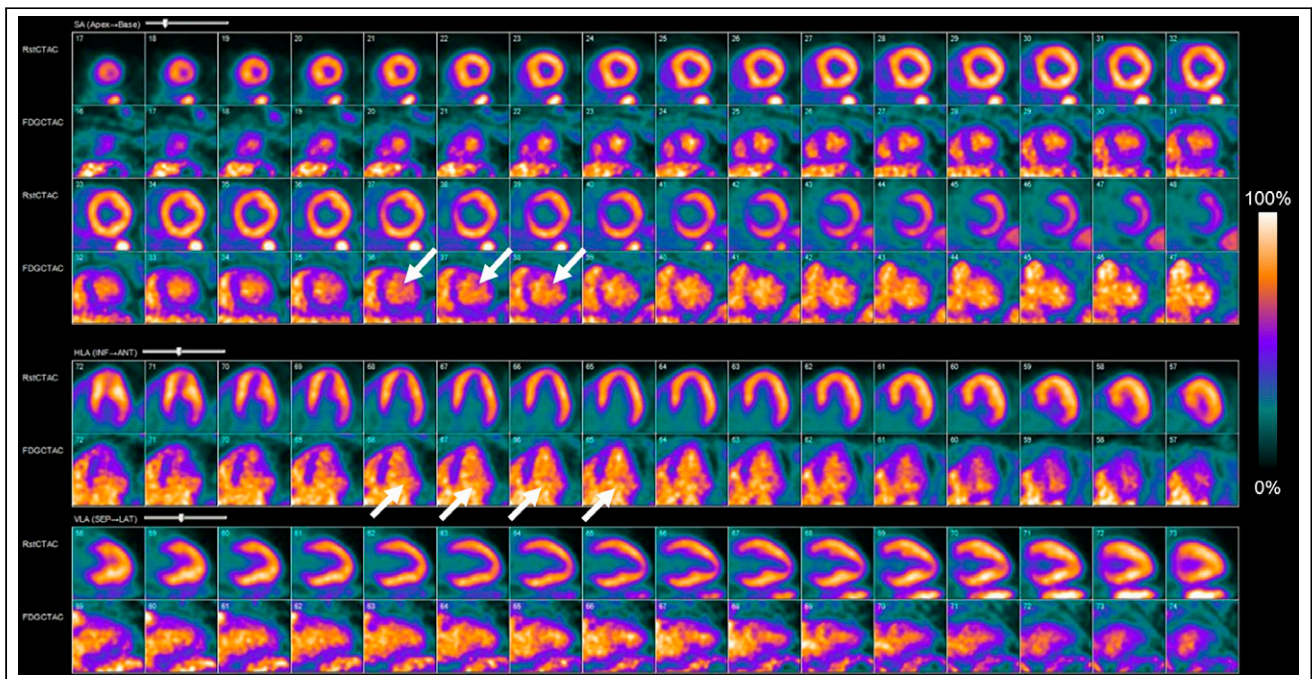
Scan 1 ^{82}Rb -chloride rest perfusion (top rows) and rescaled ^{18}F -FDG cardiac metabolism (bottom rows). Images show appropriate ^{18}F -FDG display intensity with blood-pool activity (white arrows) brighter than LV wall, indicating normal FDG uptake pattern. No evidence of any focally increased ^{18}F -FDG uptake in LV myocardial wall is seen, which indicates negative examination for active cardiac sarcoidosis.
